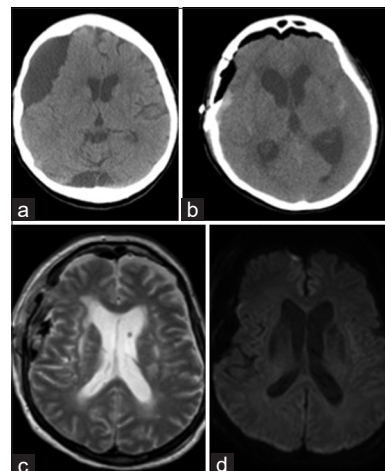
(a and b) Axial head computed tomography scan, (c) T2-weighted axial magnetic resonance imaging scan, (d) Axial diffusion weighted magnetic resonance imaging scan. (a) Large right frontal arachnoid cyst with mass effect. (b) Acute hydrocephalus that developed postoperatively with dilation of the lateral and third ventricles. (c) Improvement in hydrocephalus after external ventricular drain placement. (d) No signs of infarction.
